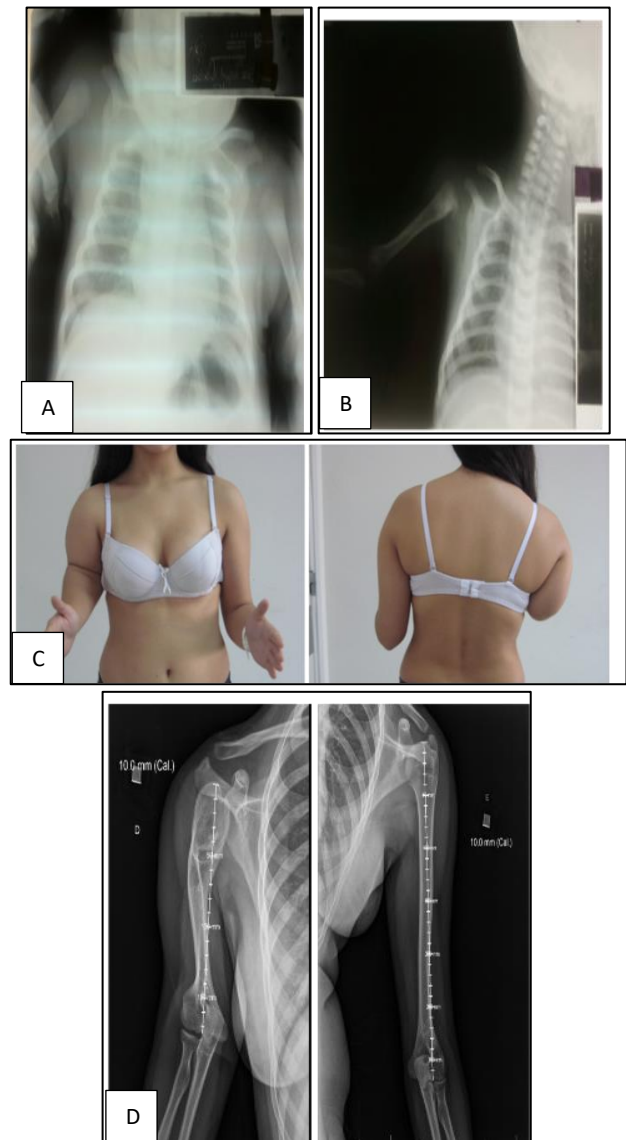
(A-D). Patient 8; initial antero-posterior radiographs of the shoulders; anterior and posterior picture of the patient and antero-posterior radiographs of the shoulders at time of last follow-up.
